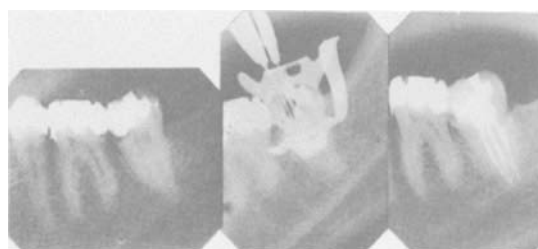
(Left Diagnostic radiograph of  $\bar{6}$  |. (Right) Completed root filling, using silver cones and AH 26, plus accessory gutta percha cones.
